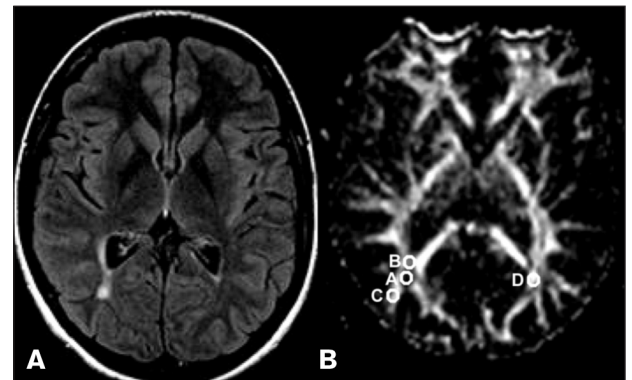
Axial FLAIR (A) MR imaging showing a plaque adjacent to the posterior horn of the right lateral ventricle. The FA map (B) demonstrates the position of the ROIs with the following values of fractional anisotropy: A=0.255; B=0.385; C=0.515 and D=0.565.
